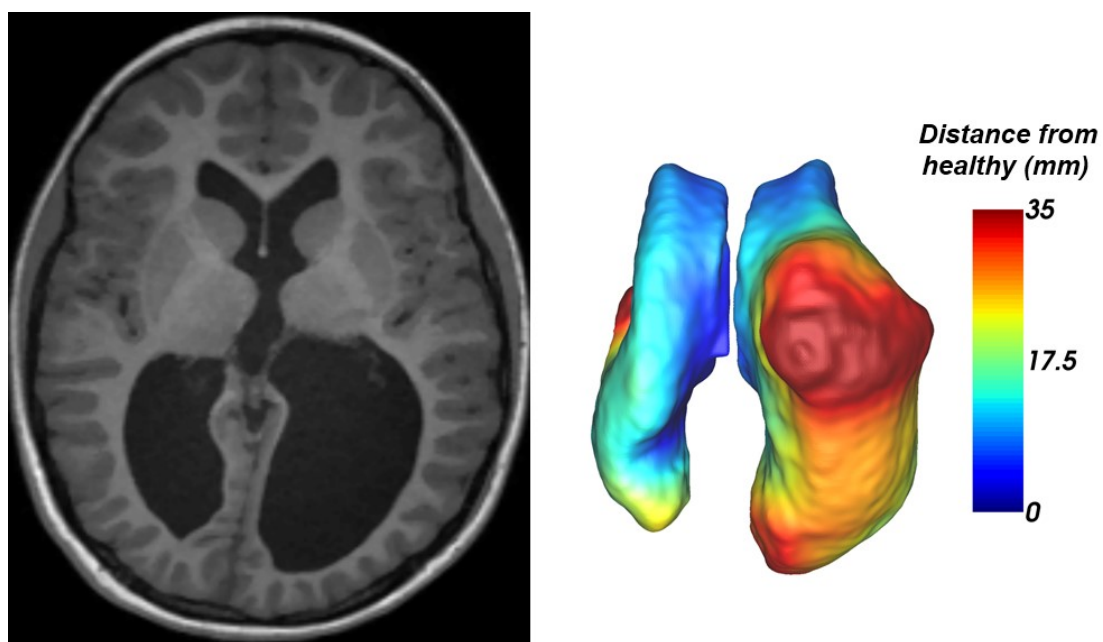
A structural MRI displaying severely enlarged lateral ventricles, and the measured Euclidean distance between the transformed healthy SSM and the segmented ventricle displayed on the ventricle mesh. This distance revealed up to 3.5cm of enlargement due to injury, observed in the superior portion of the ventricle.
